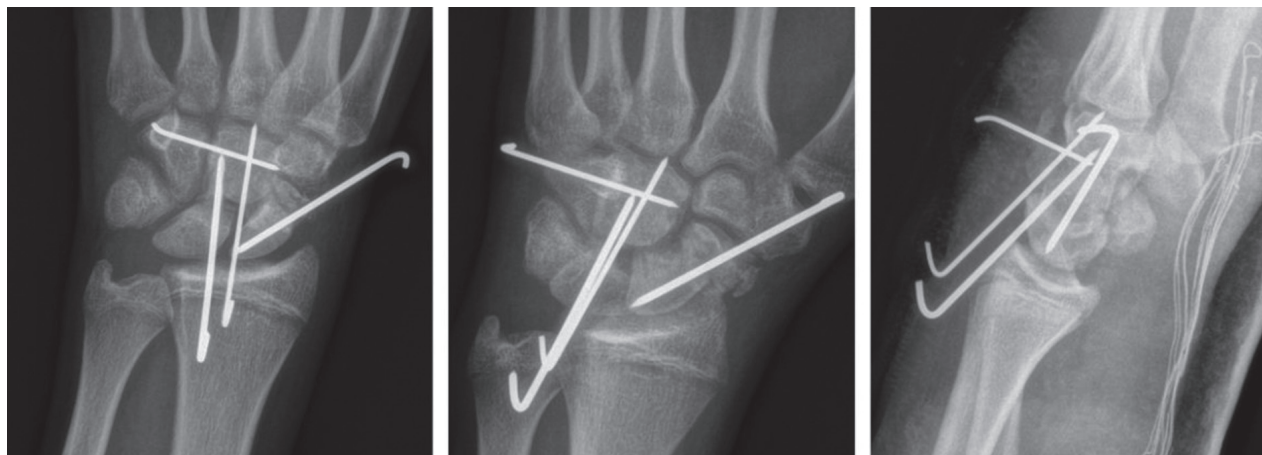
Postoperative x-ray views.
